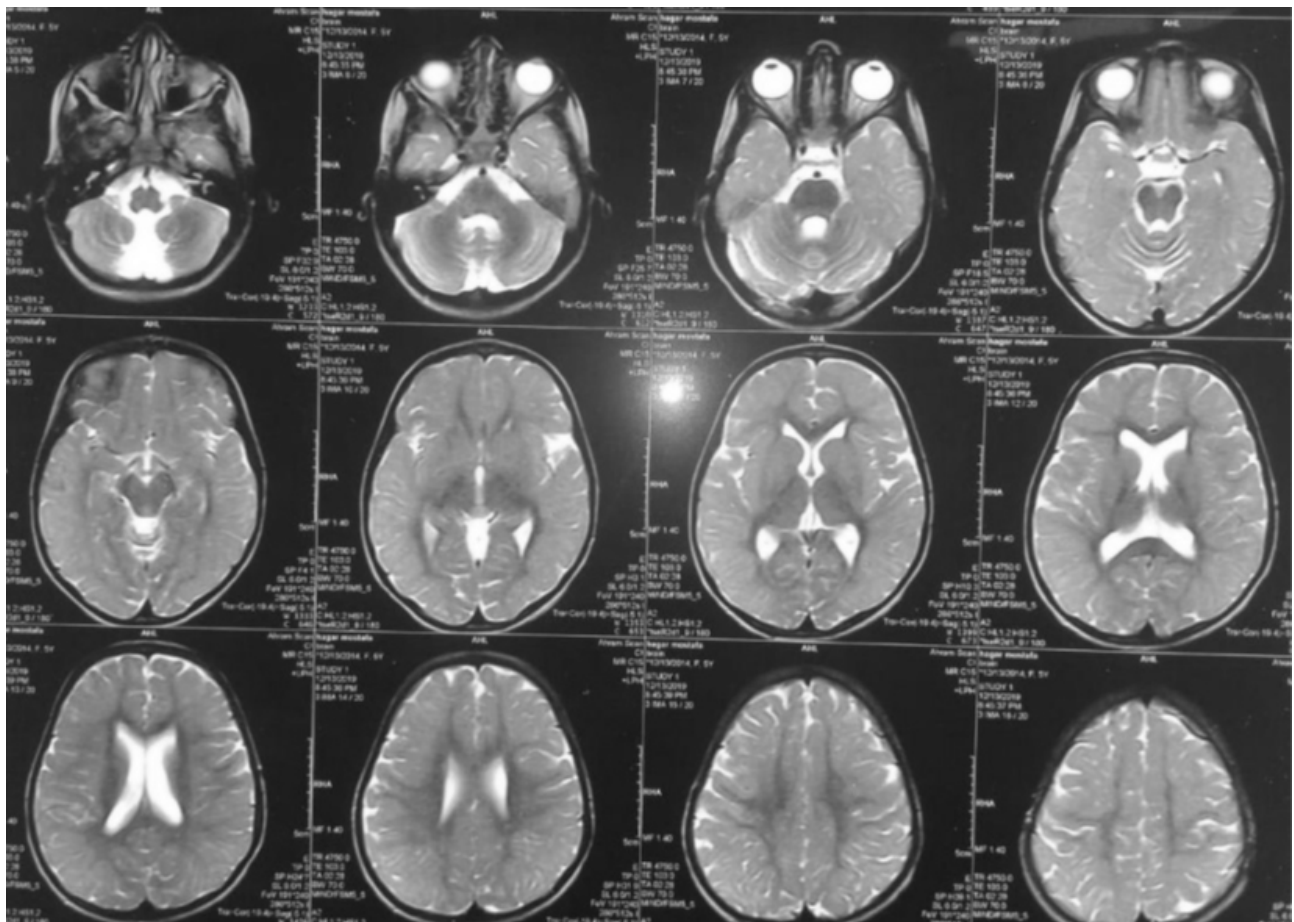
Magnetic resonance imaging (T2) showing a dilated ventricular system and prominent cerebellar folia denoting cerebellar atrophy.
